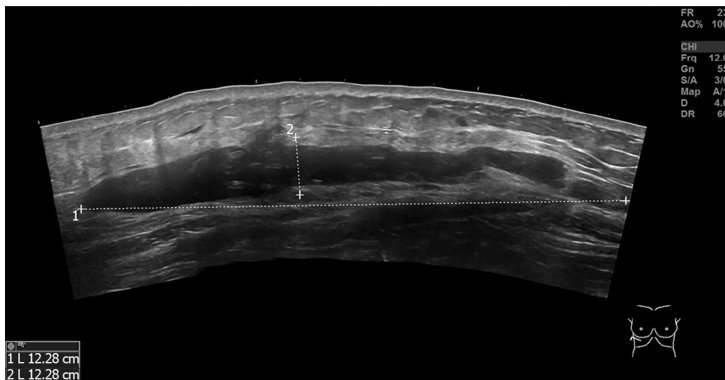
Ultrasonography of the bilateral hypochondriac region demonstrating that there was a hypoechoic area shaped like a bar on each side.
